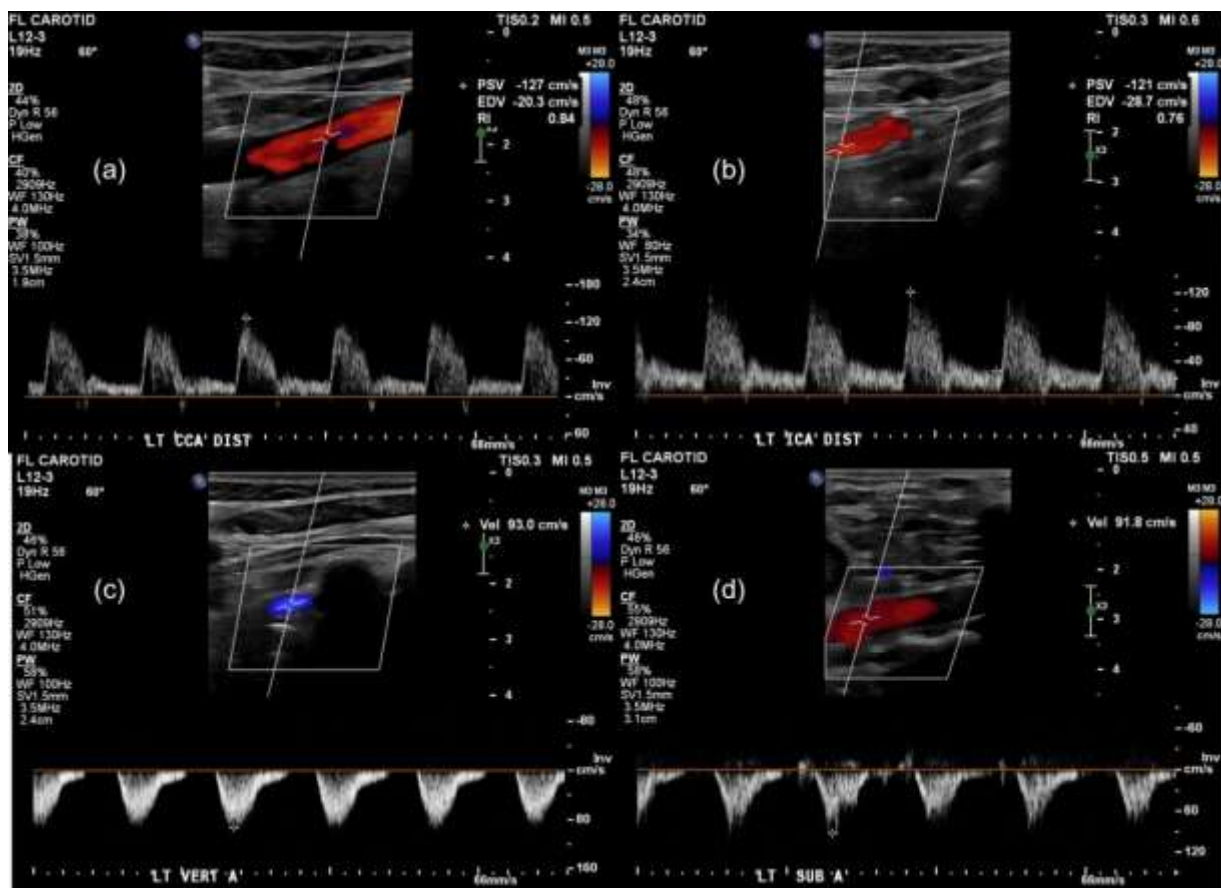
Left carotid doppler ultrasound in 79-year-old female showing antegrade flow in the left common (a) and internal carotid (b) artery and retrograde flow in left vertebral (c) and subclavian (d) arteries.
